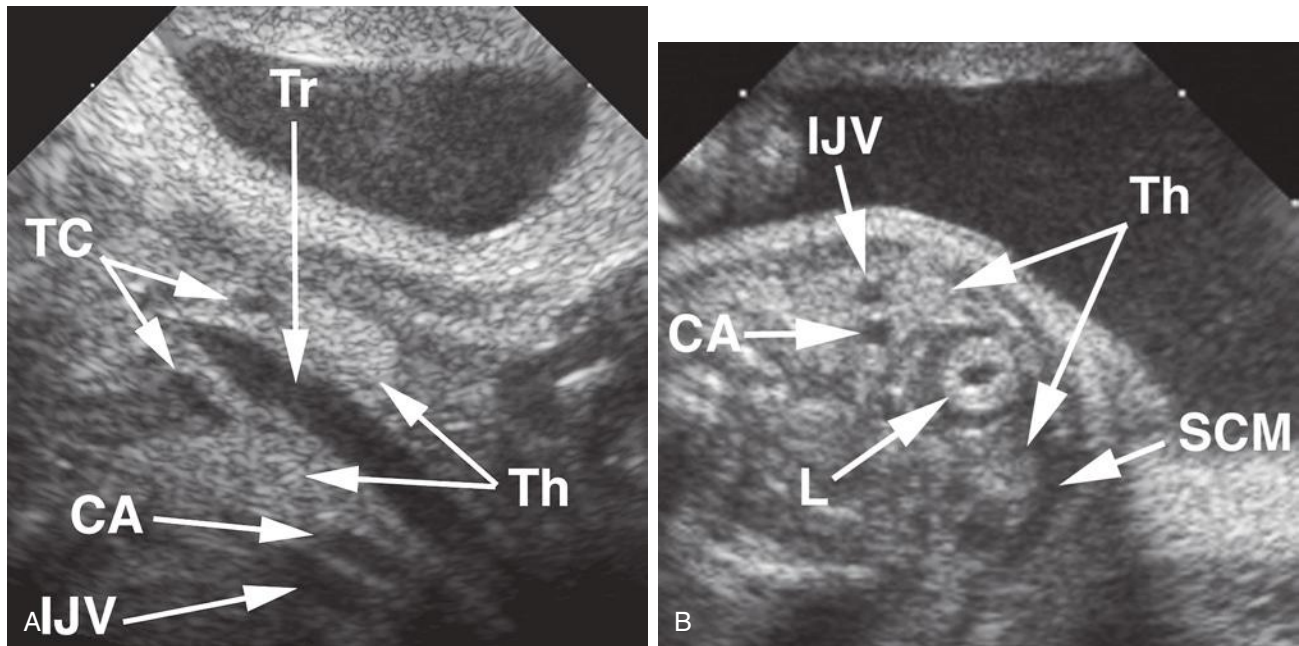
Longitudinal (A) and axial (B) sonograms of the fetal neck. CA, carotid artery; IJV, internal jugular veins; L, larynx; SCM, sternocleidomastoid muscle; TC, thyroid cartilages; Th, thyroid lobes; Tr, trachea.
